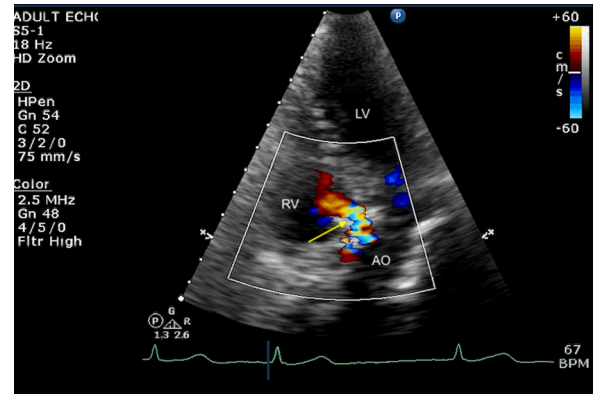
Two-dimensional TTE apical 5-chamber view with color flow Doppler demonstrates the ARV fistula (arrow), with flow from the AO to the RV. The fistula measured 0.87 cm in this view. AO, Aorta.
